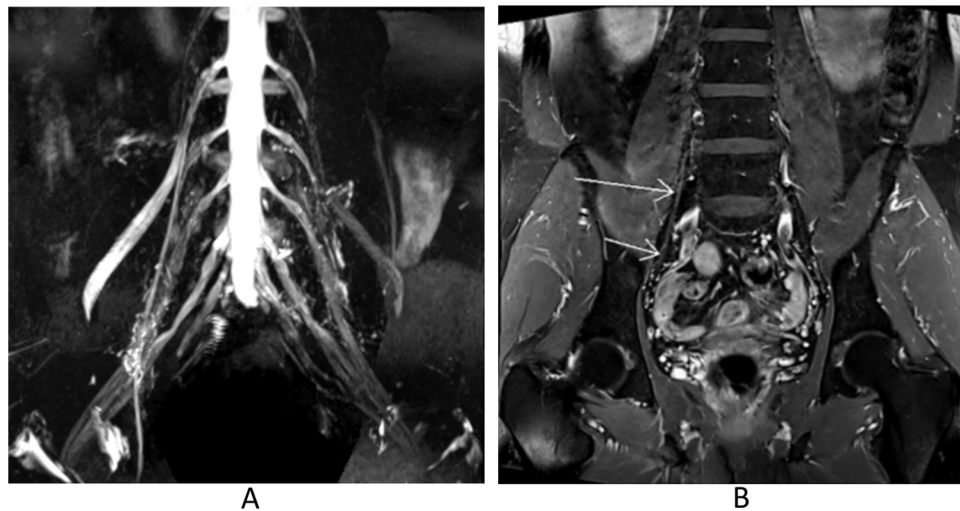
MRI of the lumbosacral plexus, coronal STIR (A) and T1 after gadolinium-injection (B), showed a bifocal involvement of both the right obturator nerve and the right femoral nerve associated with a discrete enhancement of those nerves after gadolinium-injection.
